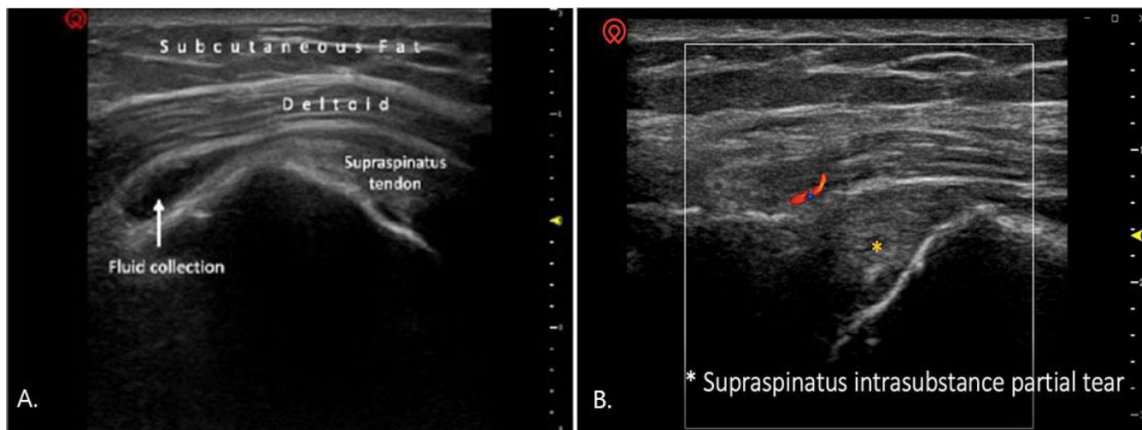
Ultrasound examination of the right shoulder, A. Tear-drop appearance, B. Supraspinatus intrasubstance partial tear
